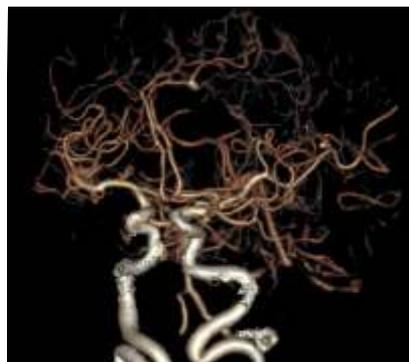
CTA brain showing the DACA aneurysm
